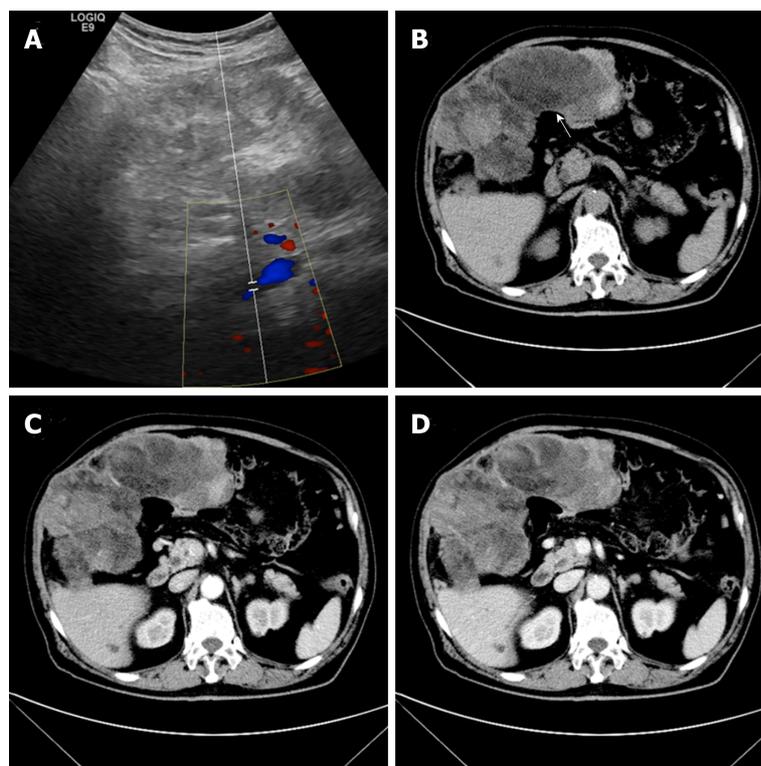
Imaging diagnosis. A: Color Doppler image showing blood flow; B: Computed tomography with contrast (white arrow, fat density); C: Uneven heterogeneous enhancement in the arterial phase; D: Delayed enhancement in the venous phase.
